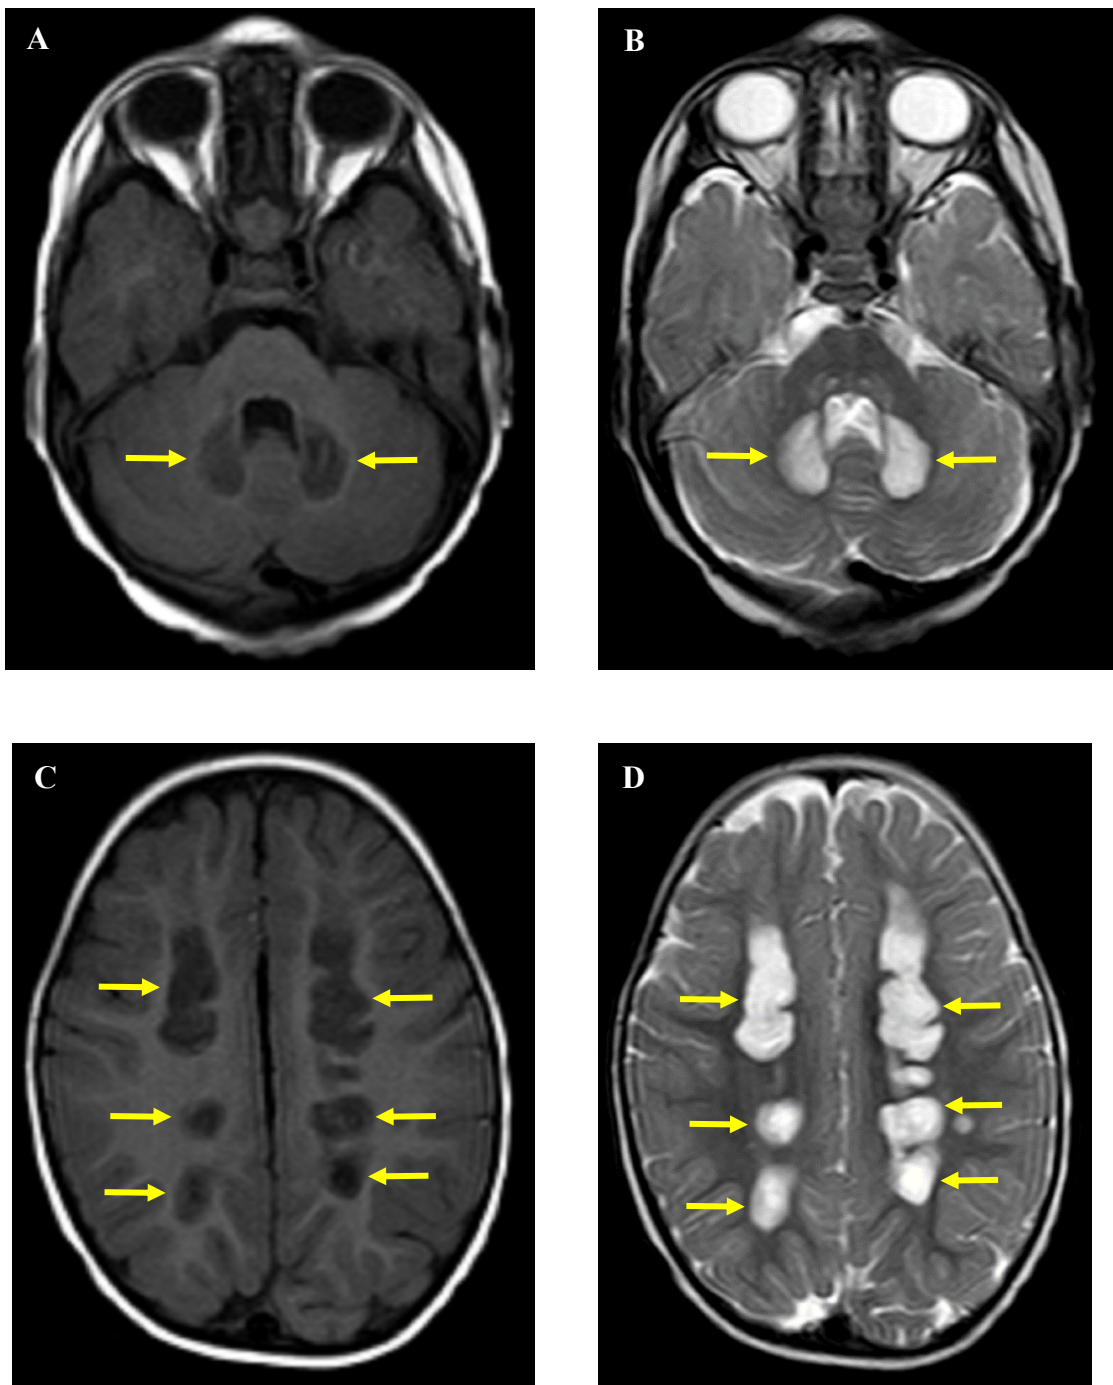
Brain MRI radiological findings in Patient 9
